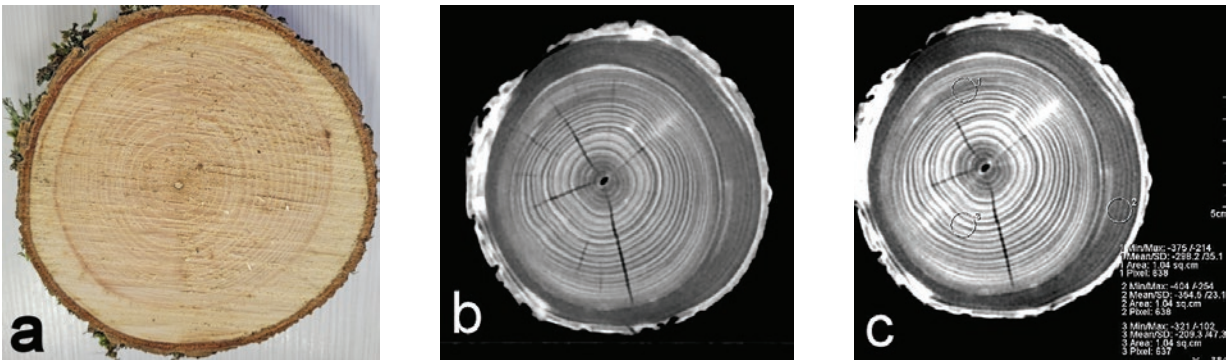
Sample Lonja 1, a) photograph, b) CT scan, c) CT scan with ROI values
